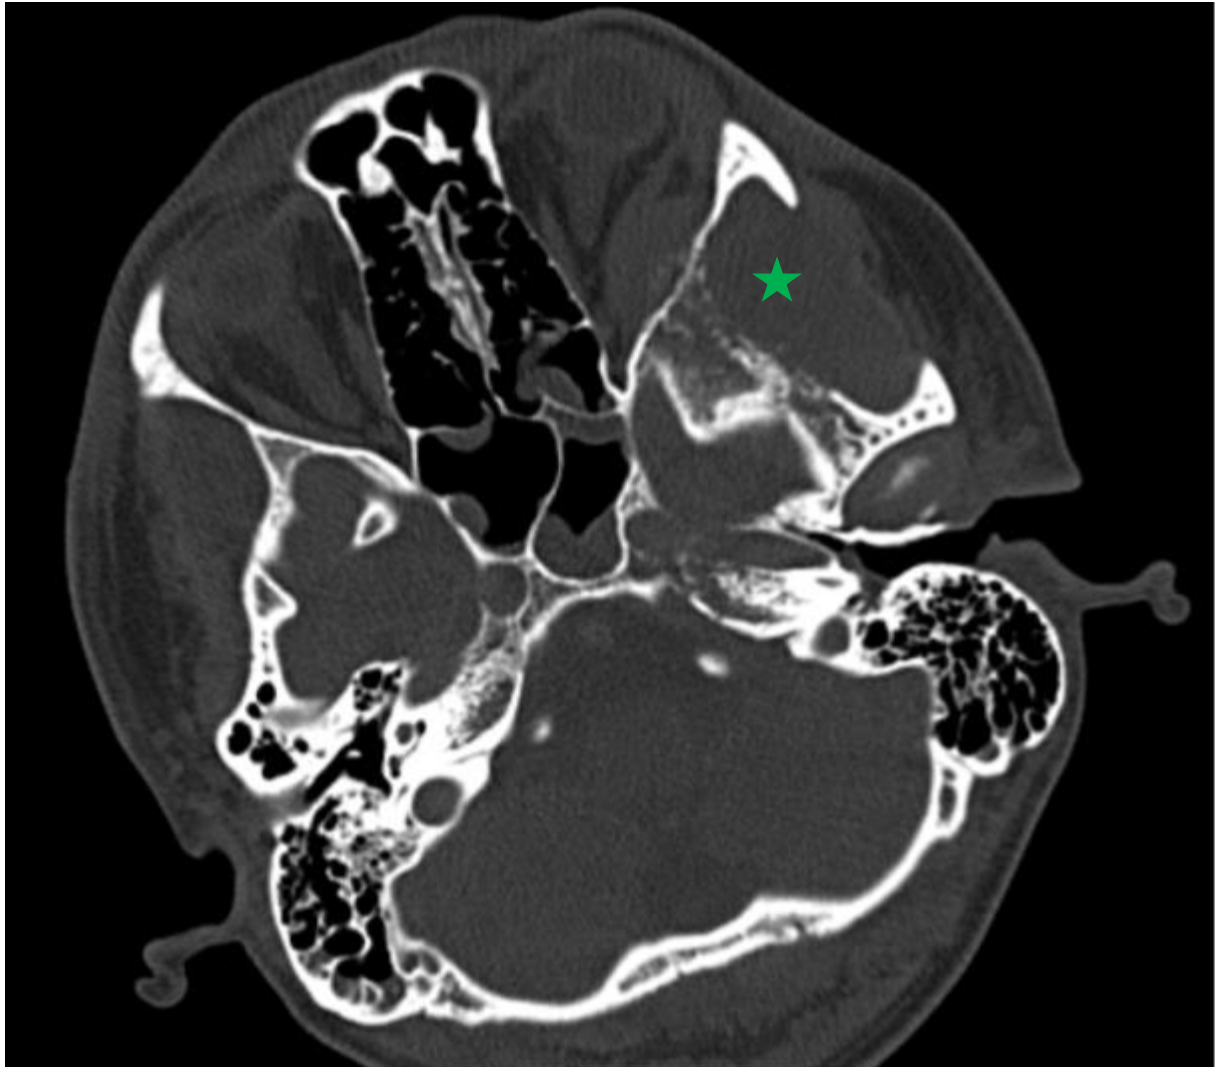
Axial CT scan (bone window) showing an aggressive osteolytic lesion (green star) of the greater wing of the right sphenoid bone with orbital extension.
